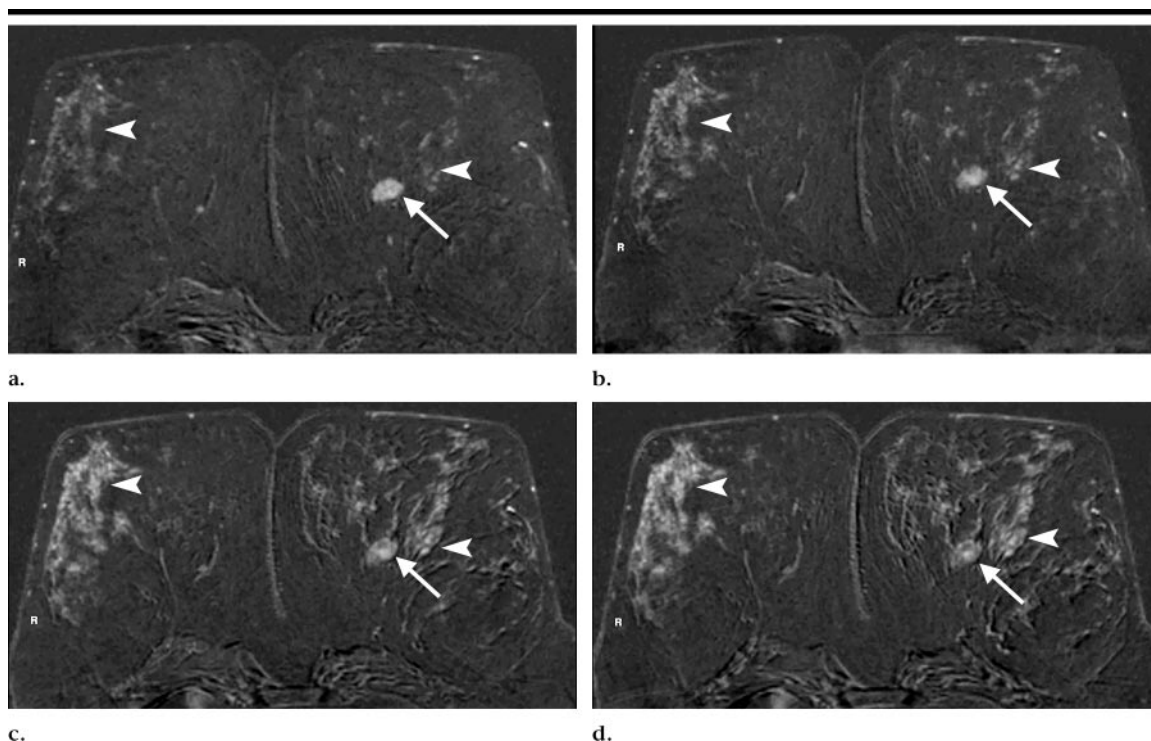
Transverse postcontrast dynamic subtracted MR images (270/4.6 [repetition time msec/echo time msec] and 90° flip angle) obtained at standard two-dimensional (2D) gradient-echo dynamic MR imaging (temporal resolution, 69 seconds per dynamic acquisition; imaging matrix, 256 × 256) of 53-year-old woman with invasive ductal cancer. Same section is displayed throughout dynamic series at (a) 69 seconds, (b) 2 minutes 18 seconds, (c) 3 minutes 27 seconds, and (d) 4 minutes 36 seconds after contrast material injection. Note that contrast between cancer (arrow) and normal fibroglandular tissue on both sides (arrowheads) is best in early postcontrast phase (a). Owing to strong washout effect in the cancer and progressive increase in signal intensity of normal parenchyma, cancer can be overlooked already on third postcontrast image (c). Assessment of fine morphologic details will not be feasible in these delayed postcontrast images because of lack of contrast between cancer and normal tissue.
